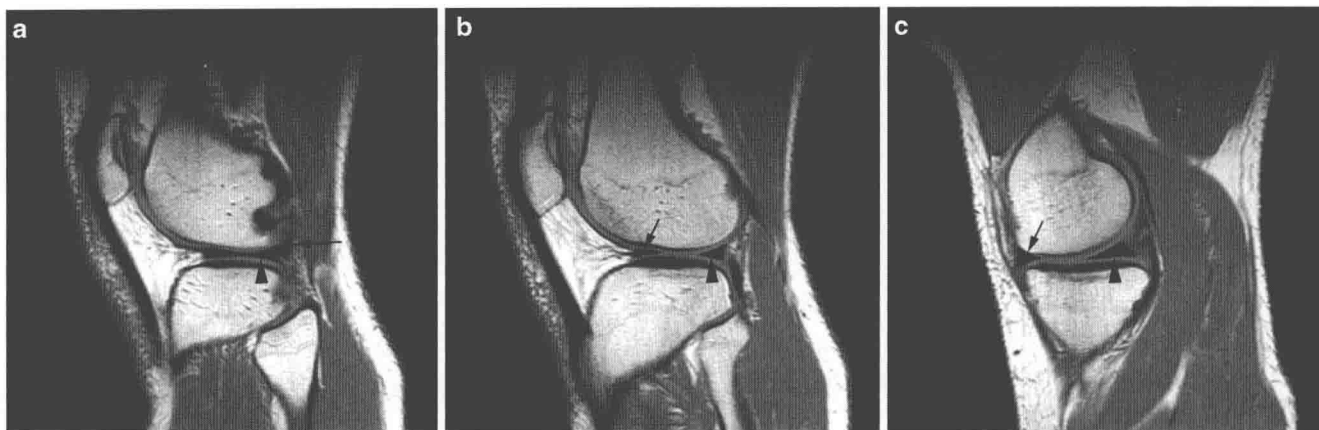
Normal meniscal anatomy. Sagittal T1-weighted images. (a) This section passes through the far lateral aspect of the lateral meniscus which shows the classic “bow tie” configuration at this point (arrowhead). The popliteus tendon is seen passing posteriorly adjacent to the posterior aspect of the meniscus (arrow). (b) This section is more
